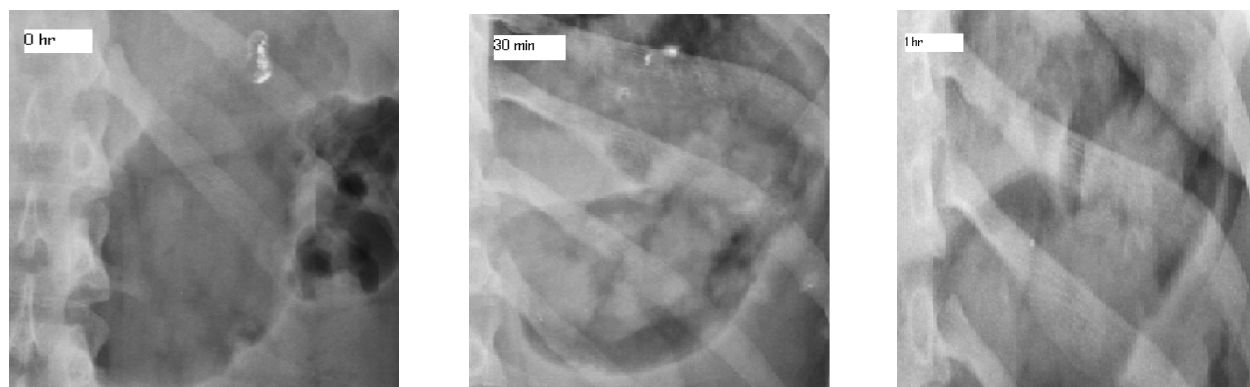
In vivo Xray studies of capsules containing only b
